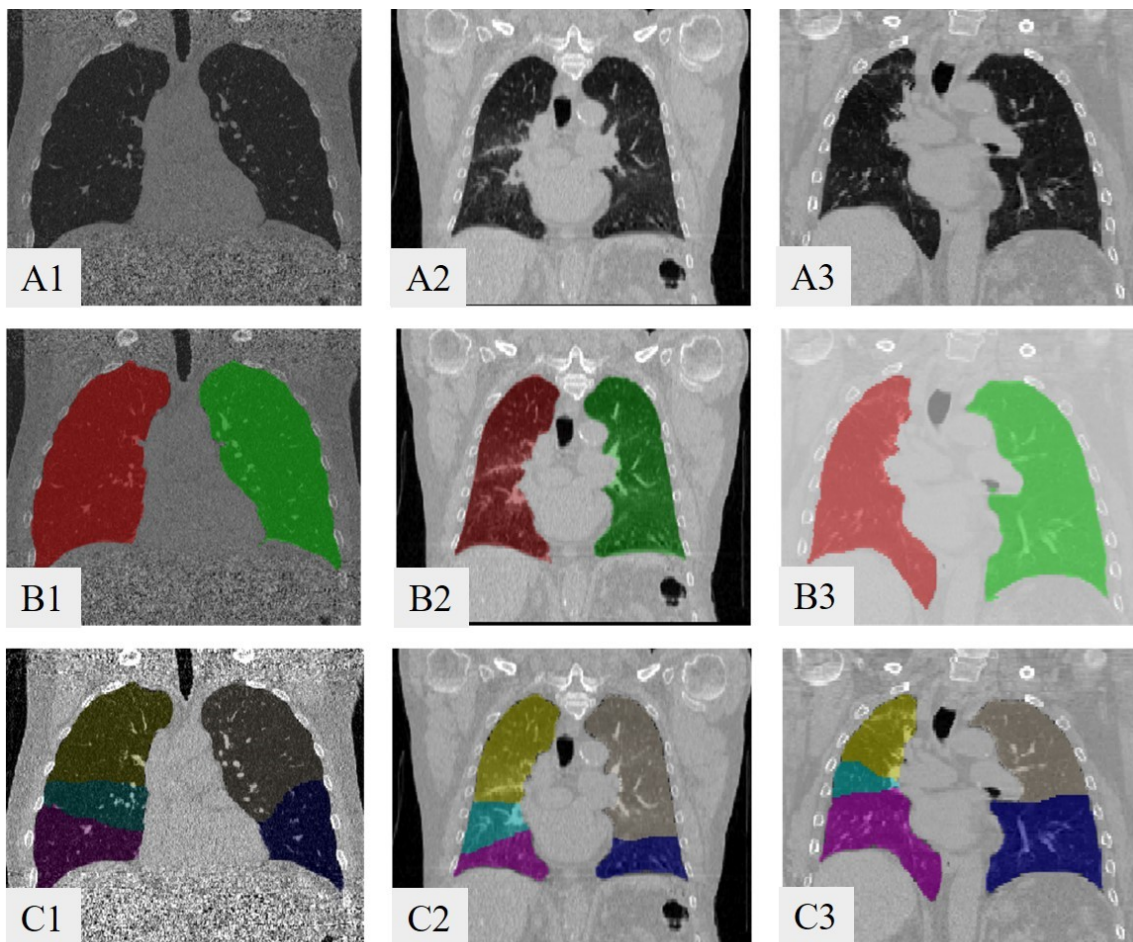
The coronal view of three patients with the CT images (A), lung masks (B), and lobe masks (C). The first column is a patient from ATM'22 dataset, the second column is a patient from the TCIA dataset, and the third column is a patient from the VAMPIRE dataset.
